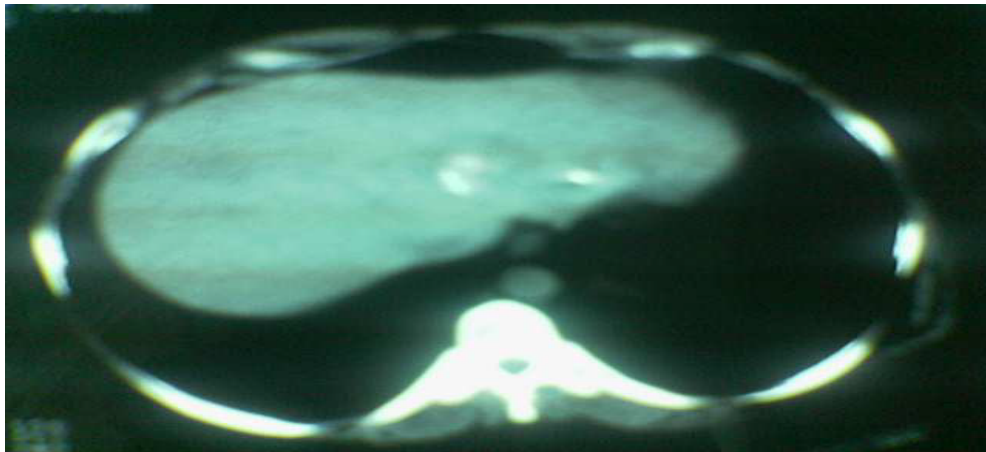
A non enhanced CT scan of the abdomen postchemoembolization showed the low density lesion in the liver is almost disappeared
